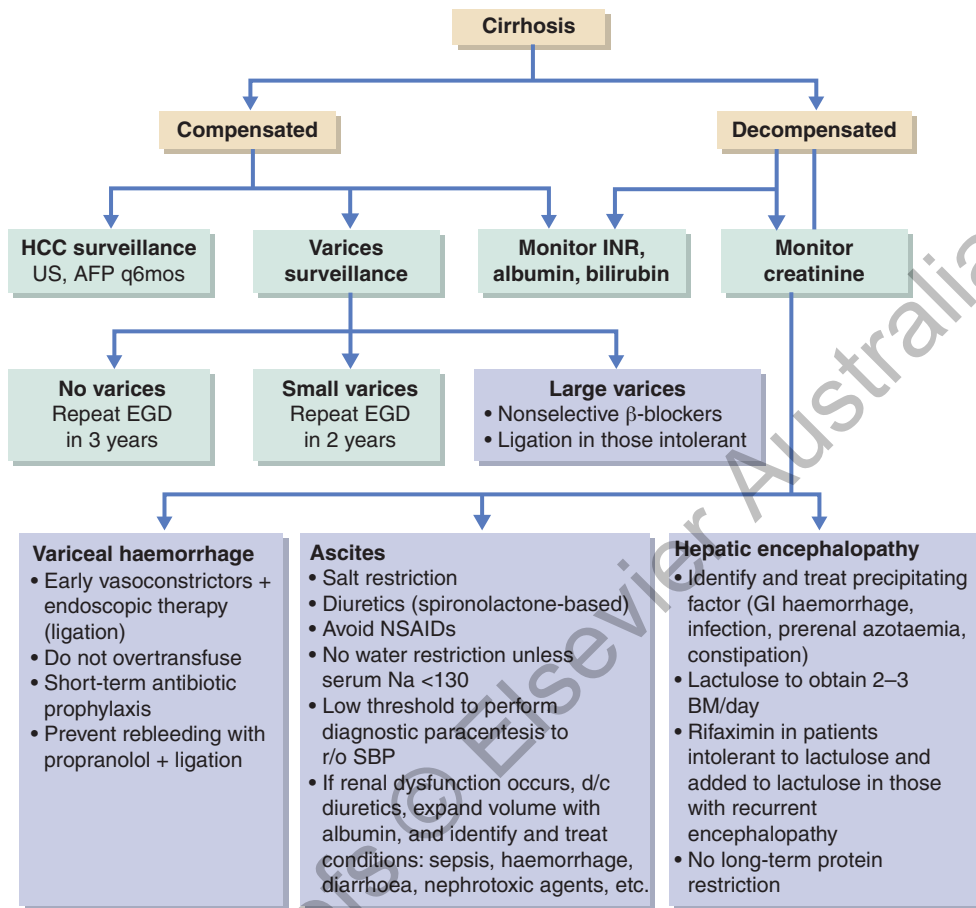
Management of cirrhosis. AFP, α -fetoprotein; BM, bowel movement; d/c, discontinue; EGD, oesophagogastroduodenoscopy; GI, gastrointestinal; HCC, hepatocellular carcinoma; INR, international normalised ratio; Na, sodium; NSAIDs, nonsteroidal anti-inflammatory drugs; r/o, rule out; SBP, spontaneous bacterial peritonitis; US, ultrasound. (Source: Goldman L, Schafer Al. *Goldman-Cecil Medicine*. 25th ed. Elsevier; 2016.)
